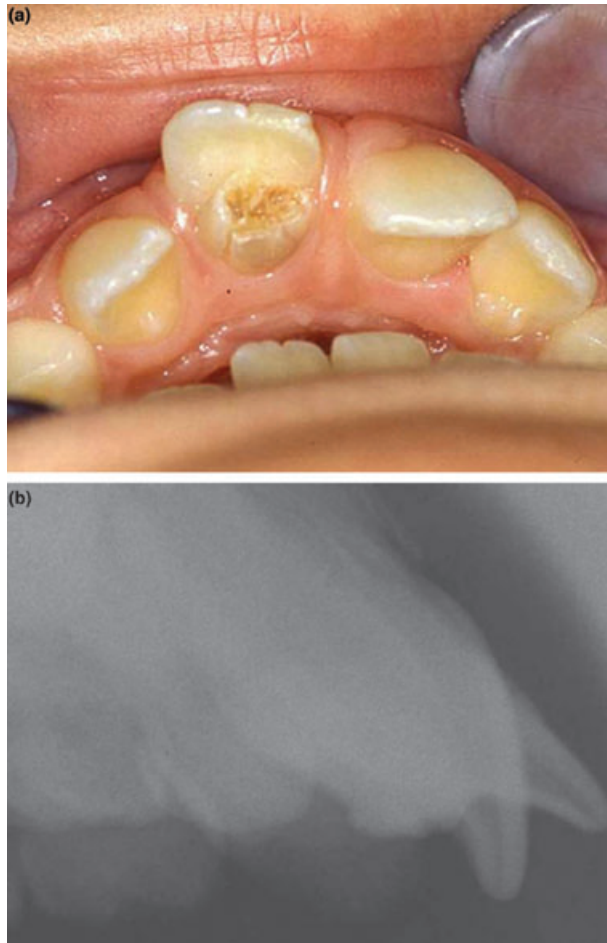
(a) Clinical image showing the displacement of the permanent maxillary right central incisor. (b) Lateral radiograph showing that the permanent maxillary right central incisor is labially displaced.
